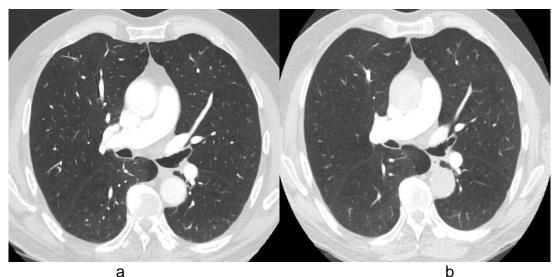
13: The lung window of the above images with no significant variance within the image quality: (a) lung window axial image obtained with the standard 100kV protocol and (b) lung window axial image obtained at the new low dose CT pulmonary angiogram protocol of 80kV.
